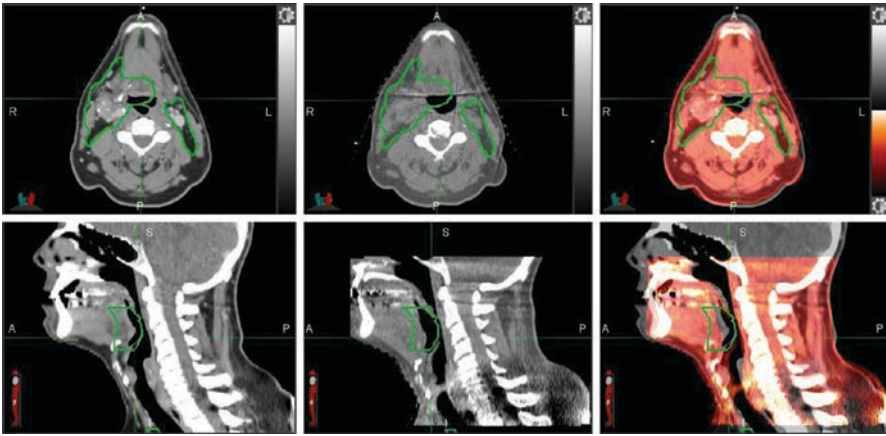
Axial and sagittal views from a planning CT (*left*), CBCT at week 2 (*middle*), and rigidly fused images (*right*) of an example H&N patient. CTV 54 Gy shown in green is overlaid on the CT and CBCT. Notice the tumor shrinkage near the base of tongue which necessitates adaptive planning
